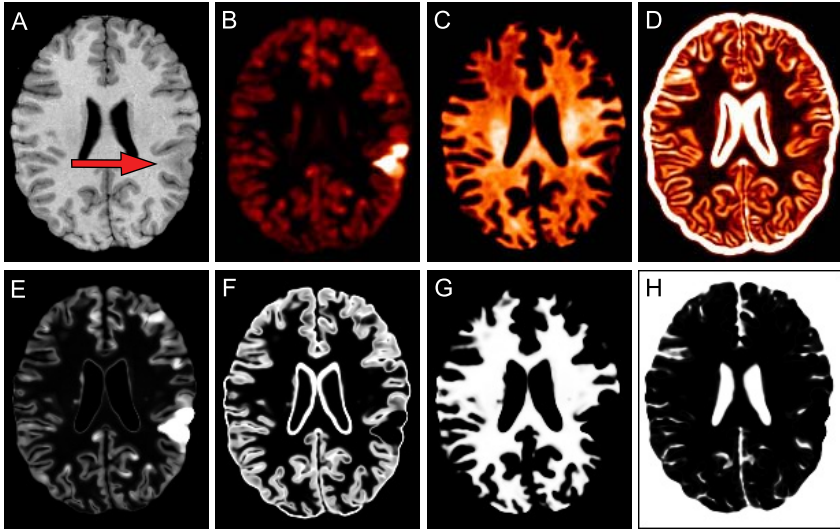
Probabilistic modeling of FCD features. Upper panels: T1-weighted MRI where the FCD lesion is indicated by the arrow (A), cortical thickness map (B), relative intensity map (C), gradient map (D). The lesion is characterized by higher cortical thickness, higher relative intensity and lower gradient. Lower panels: probability maps of the lesion class (E), GM (F), WM (G) and CSF (H).
